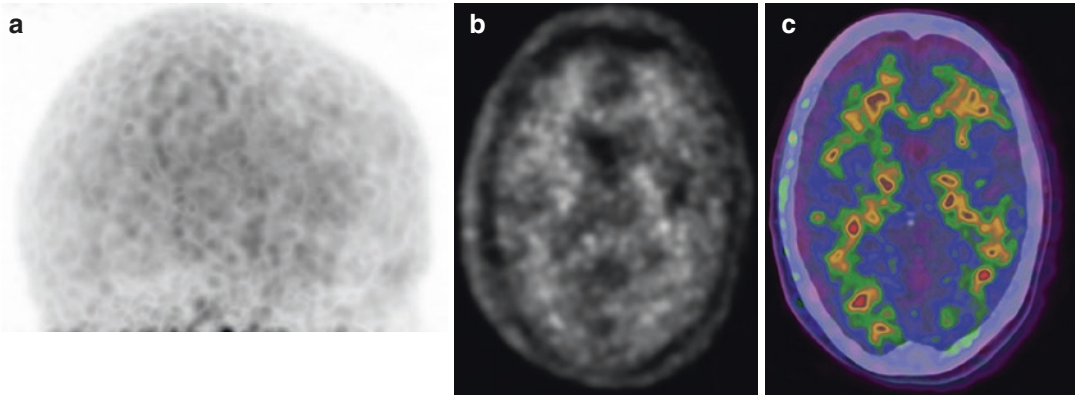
Delayed acquisition (120 min) in a 72-year-old woman showing a poor count in brain PET acquisition due to a significant washout of the radiolabeled compound (^{18}F -florbetaben). PET maximum intensity projection is showed in (a) while PET and PET/CT images are showed in (b) and (c)
